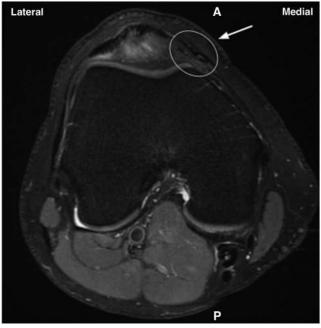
Preoperative magnetic resonance imaging scan of an axial view of the right knee. The medial patellofemoral ligament tear (white arrow) is visualized. (A, anterior; P, posterior.)
